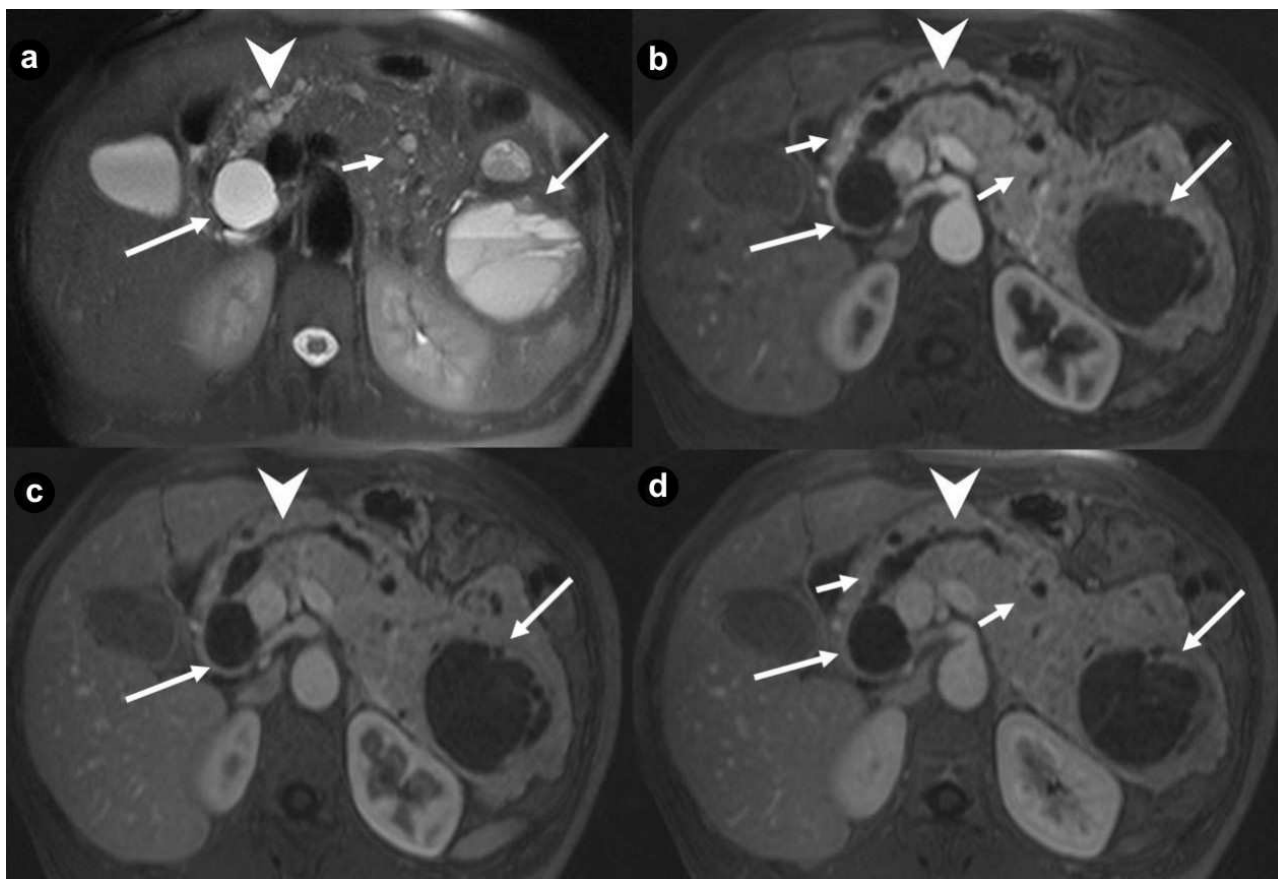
Pancreatic diffuse cystic non functioning neuroendocrine tumor. A 43-year-old woman affected by VHL disease. Axial T2-weighted MR images (a.) and 3D volumetric gradient-echo T1-weighted fat suppressed images after intravenous contrast medium administration during arterial pancreatic (b.), portal venous (c.) and delayed (d.) phases of contrastographic dynamic study.
